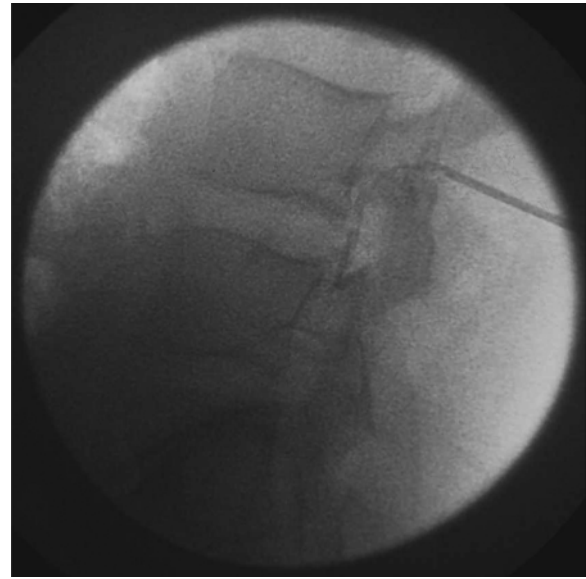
Radiograph of the epidural catheter passing caudad in the epidural space
